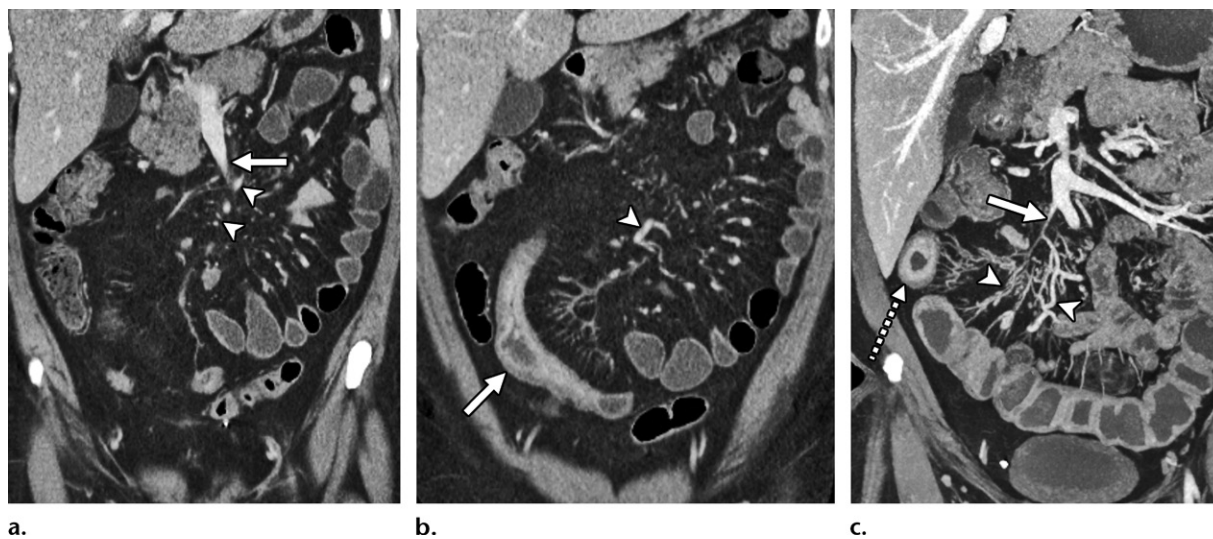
Chronic mesenteric venous occlusion in two patients with Crohn disease. (a, b) Coronal contrast-enhanced CT enterographic images in the same patient with neutral oral contrast material show chronic occlusion of the superior mesenteric vein (arrow in a) and multiple collateral veins in the mesentery (arrowheads). There are diffuse bowel wall thickening and stratified mural hyperenhancement in an adjacent segment of the ileum (arrow in b). (c) Coronal contrast-enhanced maximum intensity projection CT enterographic image with neutral oral contrast material in a different patient shows interruption of the right ileocolic vein (solid arrow) (consistent with chronic occlusion), multiple dilated mesenteric collateral veins (arrowheads), and a right-sided thick-walled ileal segment (dashed arrow) with stratified mural hyperenhancement.
